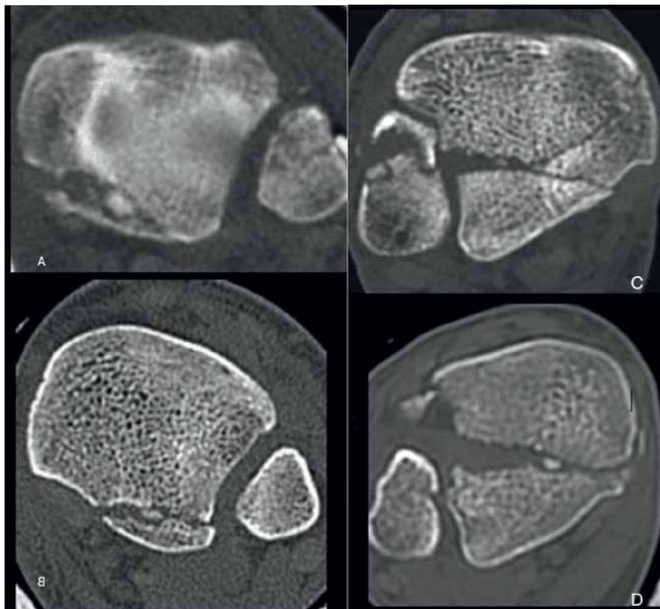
Axial CT scans showing fracture examples according to the classification of Bartoniček [21]: (A) extracisural fragment with intact fibular notch, (B) posterolateral fragment extending into the fibular notch, (C) posteromedial two-part fragment involving the medial malleolus, (D) large posterolateral triangular fragment.
